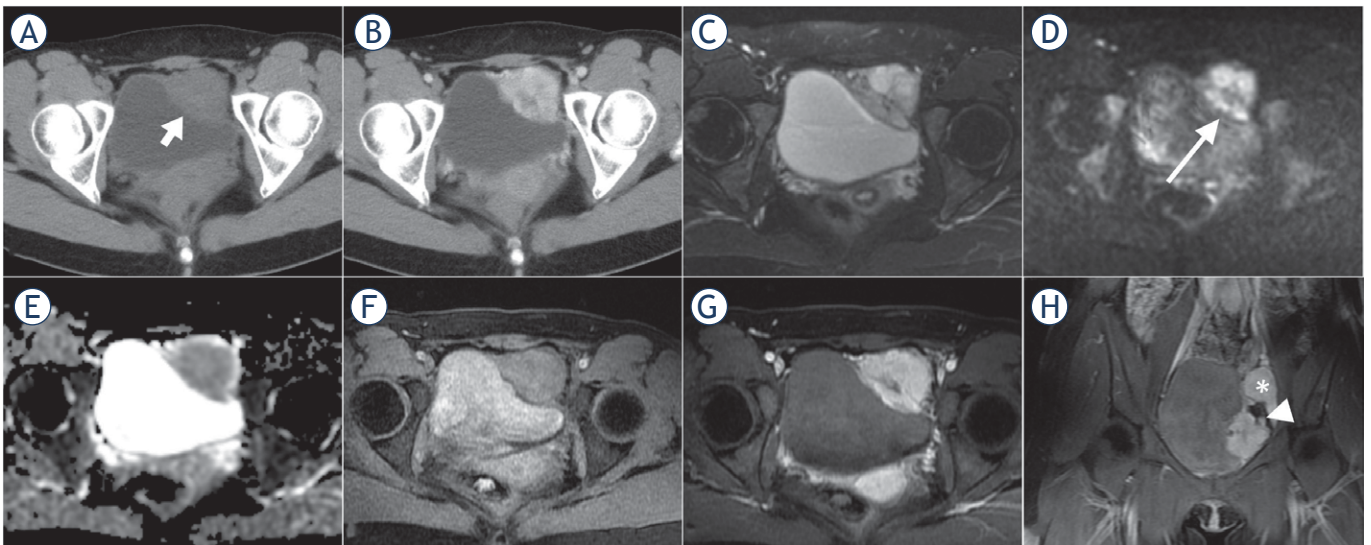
CT and MR images of a 25-year-old female with malignant bladder paraganglioma. The tumour was located in the left bladder wall with irregular shape, presenting heterogenous hypodensity (short arrow) and obvious enhancement on axial pre- and post-contrast enhanced CT images (A, B), heterogenous slight or marked hyperintensity on T2-weighted images (T2WI) (C), heterogenous hyperintensity on diffusion-weighted images (DWI) (long arrow) (D), hypointensity on apparent diffusion coefficient (ADC) maps (mean ADC value, $0.997 \times 10^{-3} \text{ mm}^2/\text{s}$) (E), slight hyperintensity compared to the gluteus maximus on T1WI (F) and early marked enhancement on arterial phase images (G). Coronal enhanced MRI showed the lesion encased the left iliac artery branch (arrowhead); a similar enhanced lesion was located next to the left iliac vessels (asterisk), suggesting multiple paraganglioma (H).
